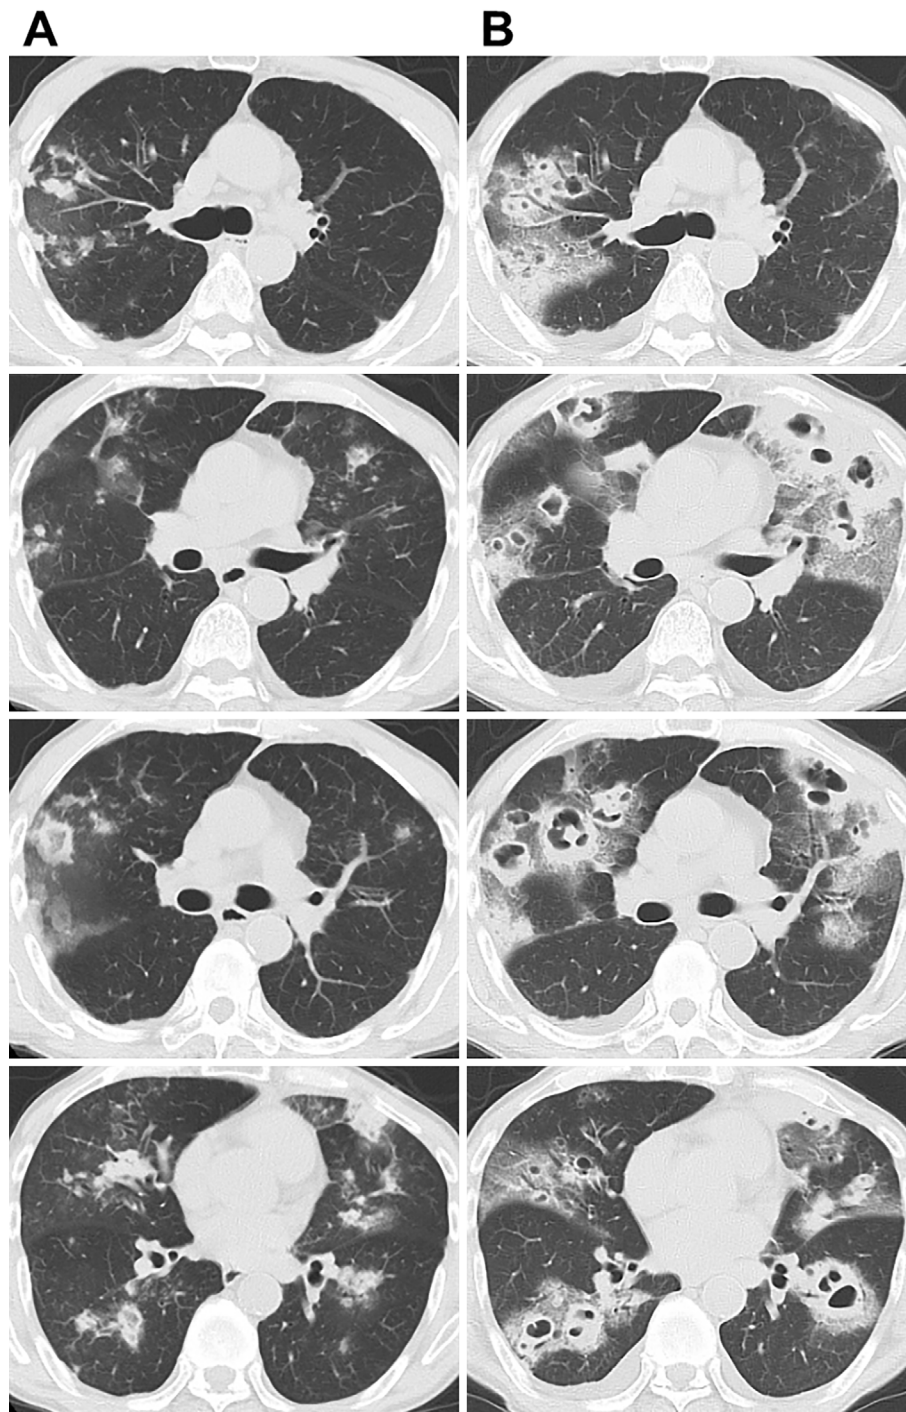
Chest computed tomography on admission at the previous hospital showed bilateral multiple patchy shadows and ground-grass opacities (A). Rapidly progressive consolidations and the formation of cavities with bilateral pleural effusion were seen on chest CT scans obtained on admission to our hospital after a short period of time (B).
